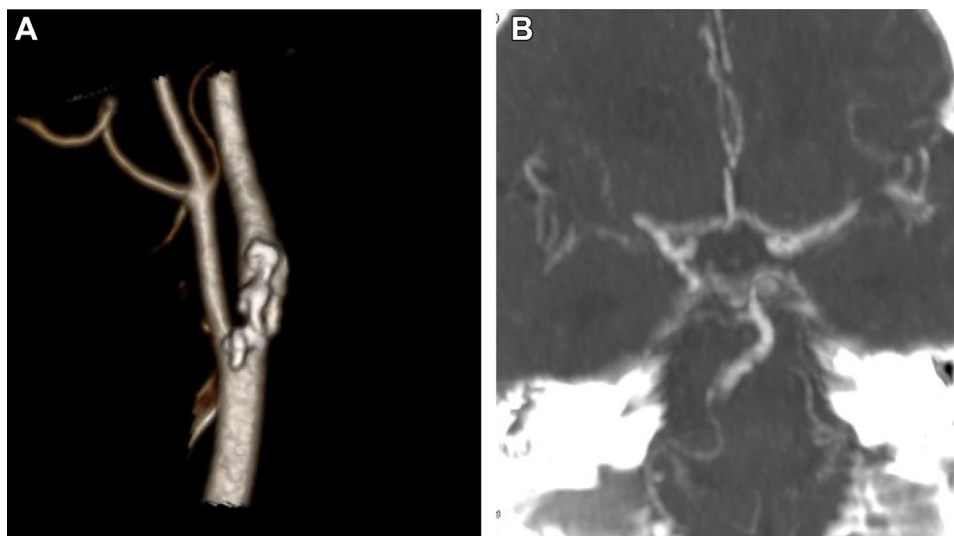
A, Three-dimensional reconstructed computed tomography angiography image of head and neck before transcarotid artery revascularization (TCAR) showing high-grade stenosis of the left internal carotid artery (ICA). B, Maximum intensity projection showing intact circle of Willis.
